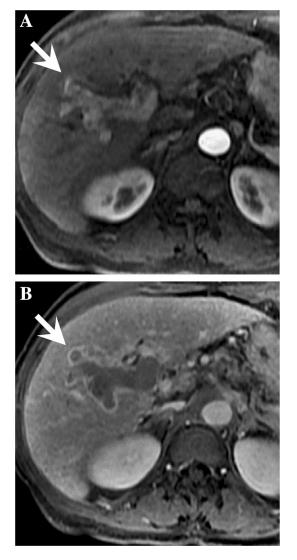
Tumor in vein (LR-TIV). Contrast-enhanced MRI in the arterial (A) and delayed (B) phases show an expansile enhancing soft tissue (arrow) in the main and right portal veins of a cirrhotic liver not contiguous with a parenchymal mass. This is consistent with LR-TIV, likely due to HCC. Note arterial phase hyper-enhancement and "washout" seen within the expanded vein.
